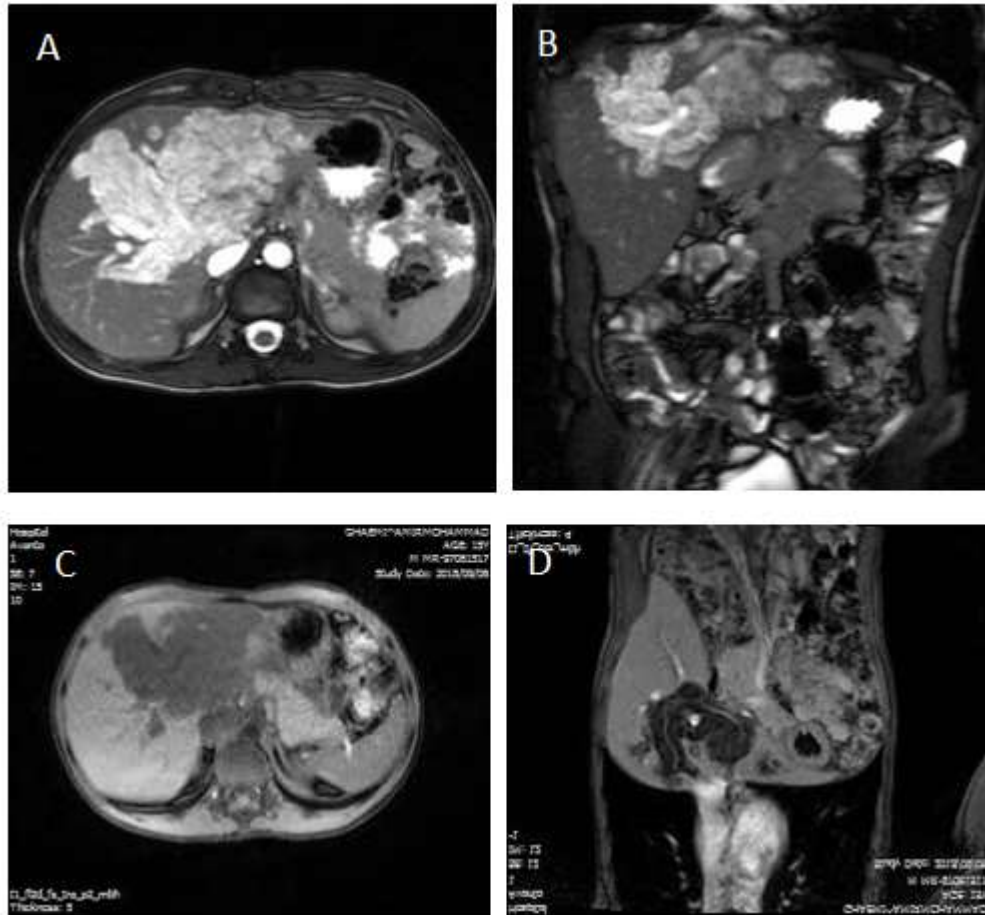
Magnetic resonance imaging of the plexiform neurofibromas involving the liver, A: T1-weighted sequences without contrast, axial view, B and C: axial and coronal views, T2-weighted sequences, D: Coronal T1-weighted images with contrast.
